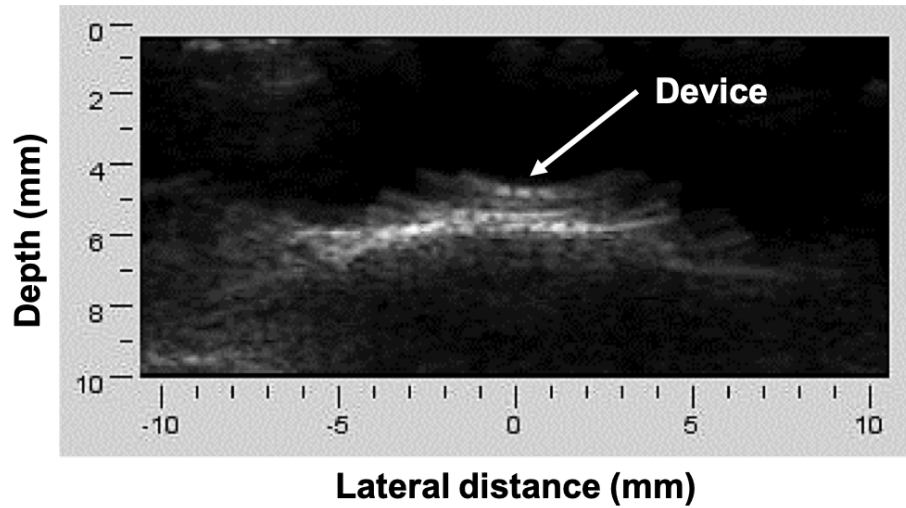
The ultrasound image showing the mote located above the skull.
